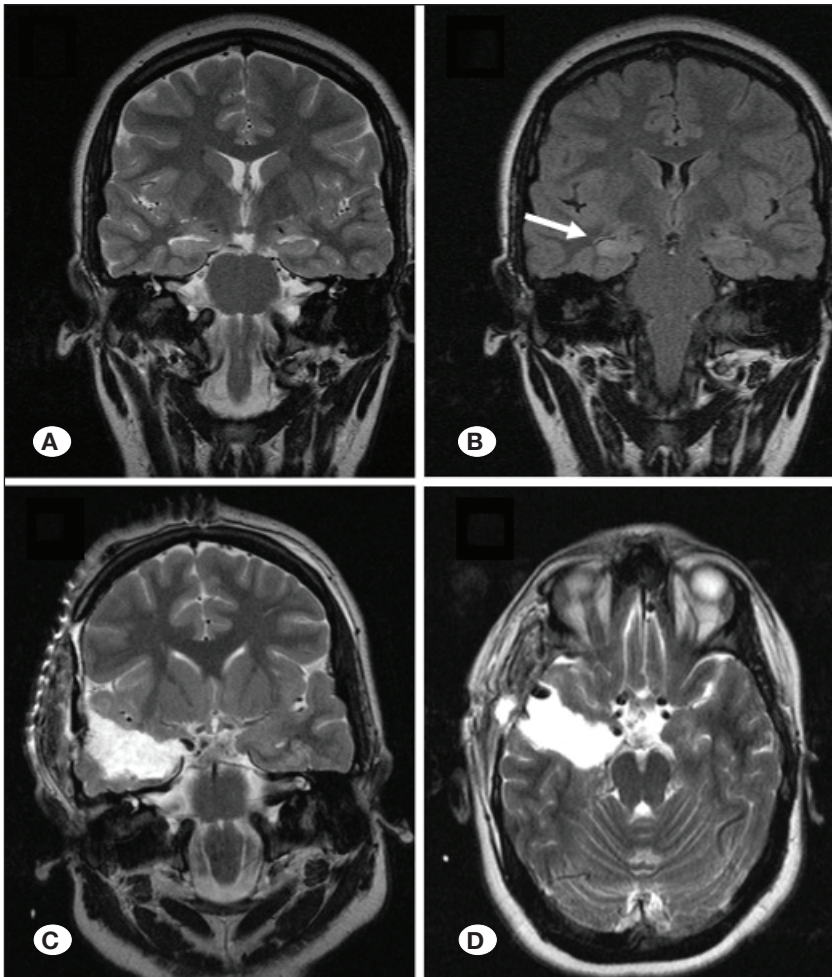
Preoperative coronal A) T2-weighted and B) FLAIR MR sections and postoperative coronal C) T2-weighted and D) axial MR sections of a patient with right-sided MTS. Right mesial temporal structures appear hyperintense in the FLAIR sequence due to sclerosis (arrow). FLAIR: Fluid-attenuated inversion recovery, MR: magnetic resonance, MTS: mesial temporal sclerosis.
